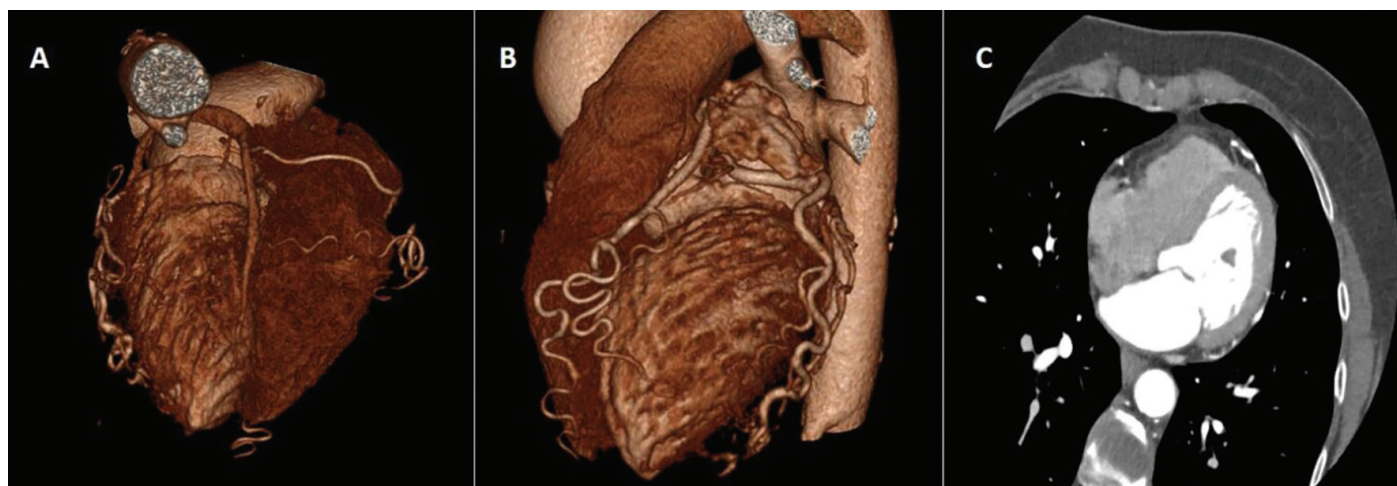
Coronary cameral fistulas on 3D computed tomography (CT) coronary angiography
